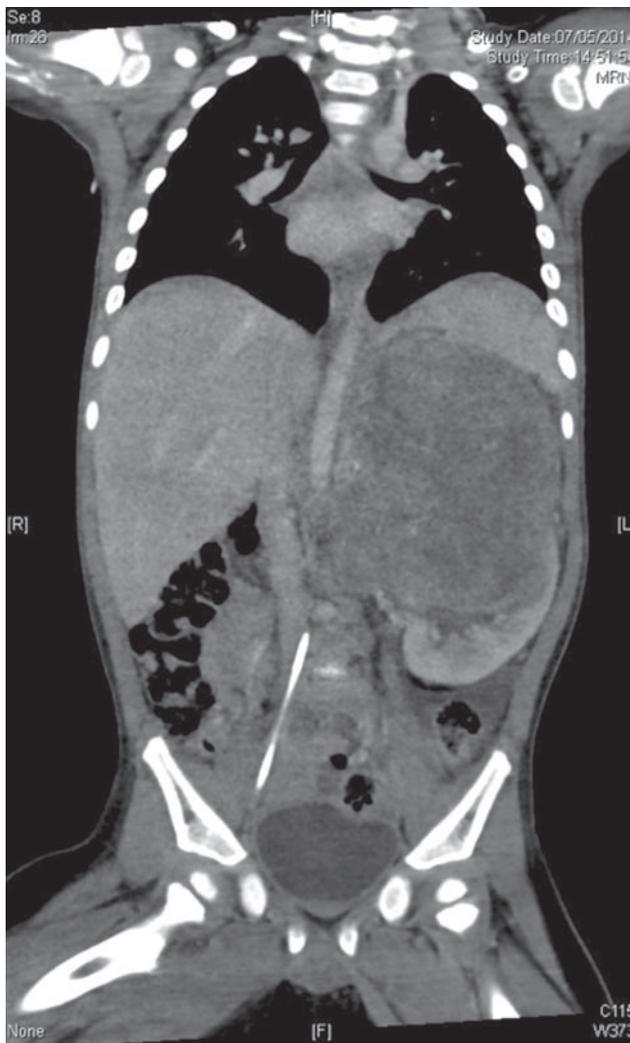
CT scan showing the left renal mass.
